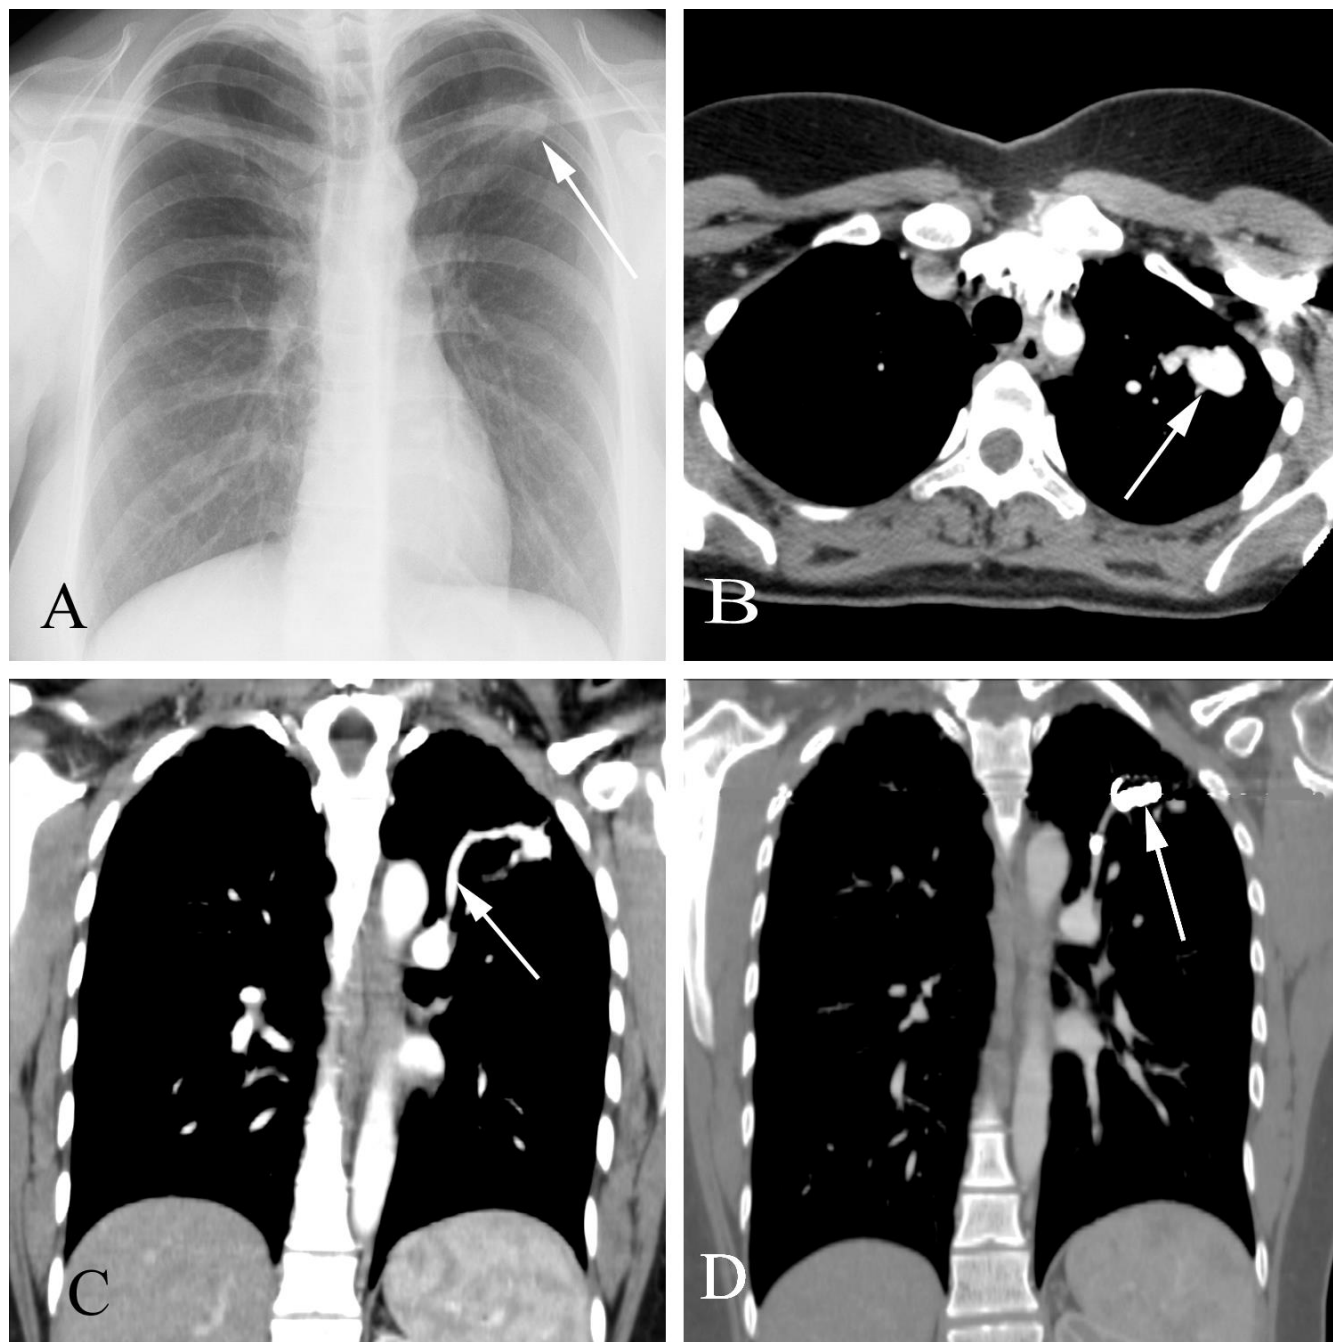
Arteriovenous malformation in a 34 year old woman with chest pain. A. Chest radiograph shows a mass in the left upper lobe. B. Axial contrast-enhanced CT shows an intensely enhancing lesion. C. Coronal reformatted contrast enhanced CT shows a feeding vessel characteristic of an arteriovenous malformation. The patient underwent embolization therapy. D. Follow-up coronal CT filmed at bone windows shows embolic material within the lesion. The patient's pain remitted following treatment.
